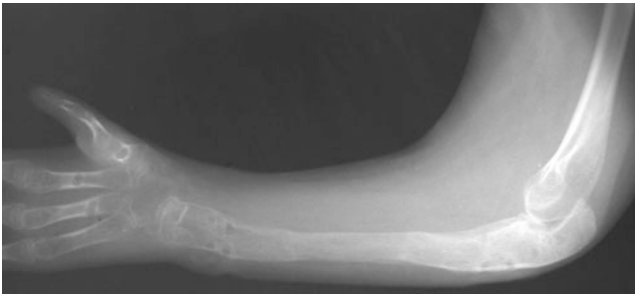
Radiographs after removal of external fixator showing excellent bone formation, length, and maintenance of wrist alignment
